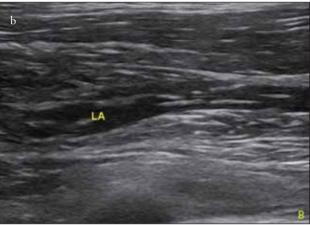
a-c. (a) Ultrasound image shows probe placement and needle insertion. (b) Local anaesthetic (LA) (c) Ultrasound image of the anterior thoracic wall shows the pectoralis major muscle (PMM), pectoralis minor muscle (pmm) and catheter
